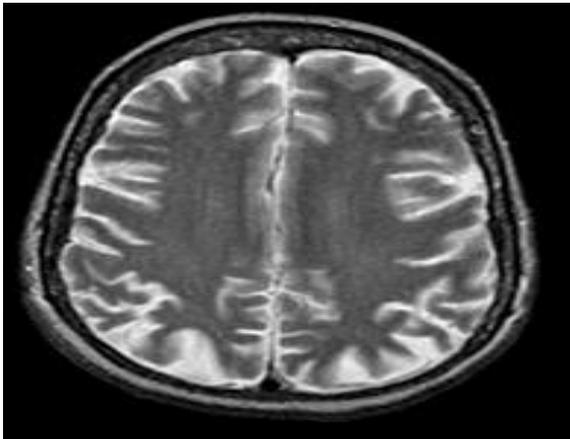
The MRI reveals moderate cerebral atrophy with mild expansion of the sulci in the hemispheres, particularly noticeable in the parietal and perisylvian areas. Perfusion SPECT shows irregularities typical of Alzheimer's disease, with decreased blood flow in temporal-parietal areas in contrast to frontal regions
